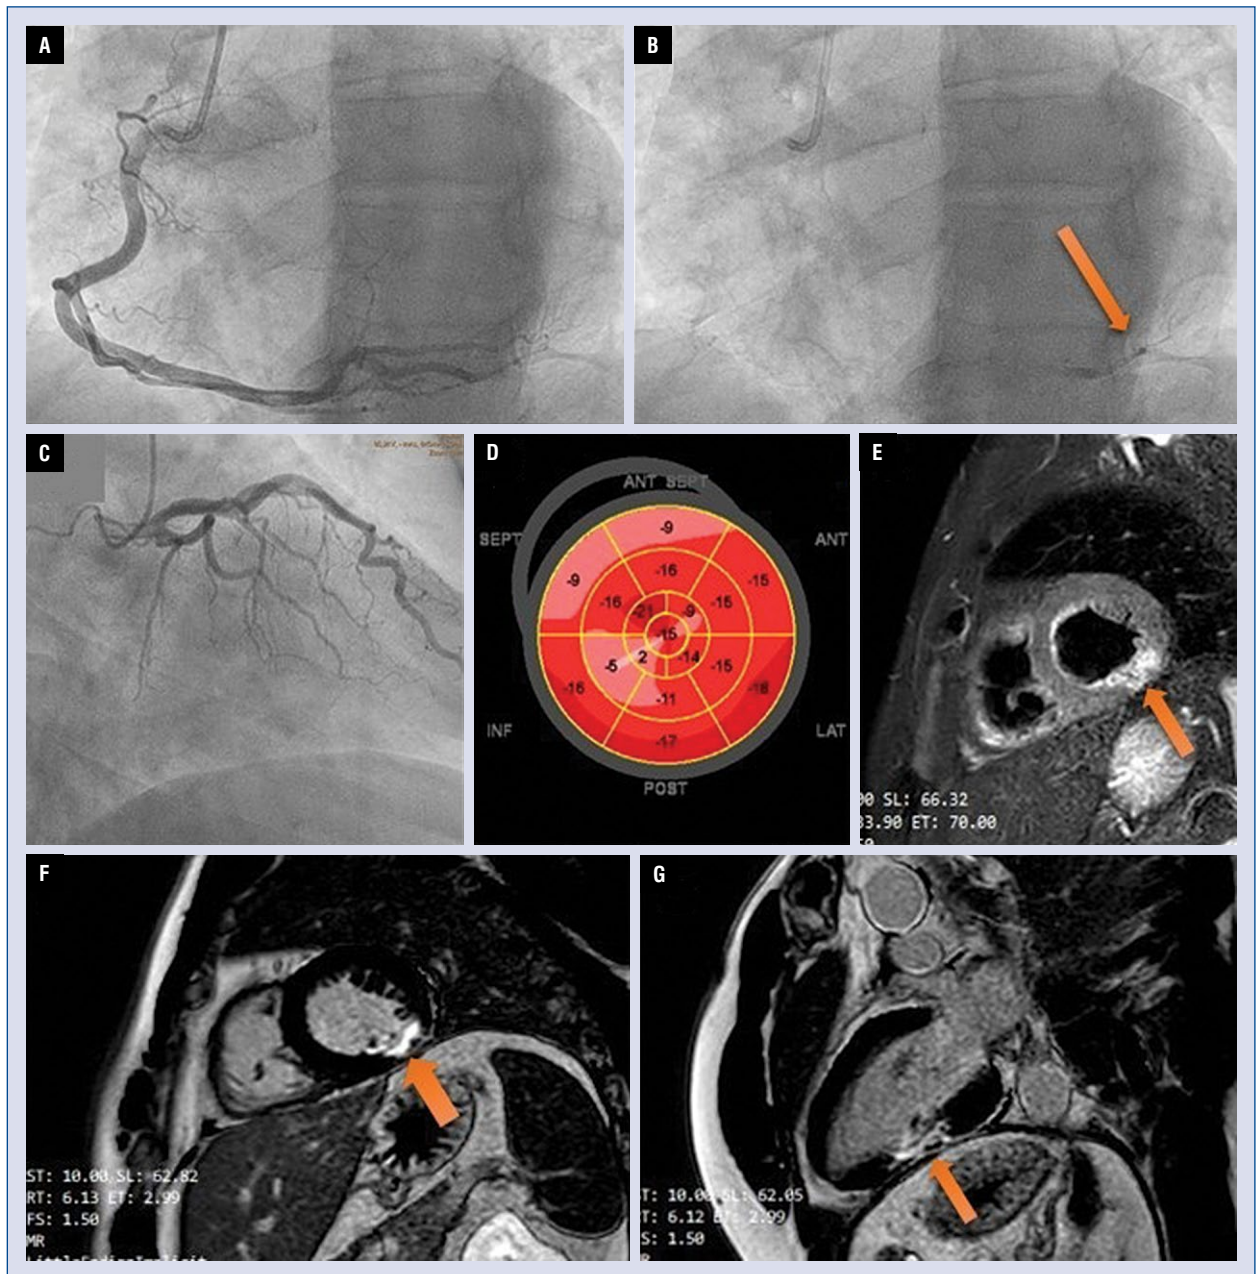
A–C. Views from coronarography; A. Right coronary artery, early phase of contrast enhancement; B. Right coronary artery, late phase, contrast retention in a minor posterolateral branch marked with an arrow; C. Normal left coronary artery with recessive circumflex artery; D. Echocardiographic examination after one year, bullseye view showing small region of abnormal local strain located in the inferolateral wall; E–G. Cardiac magnetic resonance views; E. Subendocardial late gadolinium enhancement detected in the middle and apical segments of inferolateral wall (marked with an arrow); F, G. Subendocardial high T2 signal intensity indicated myocardial edema (arrows).
